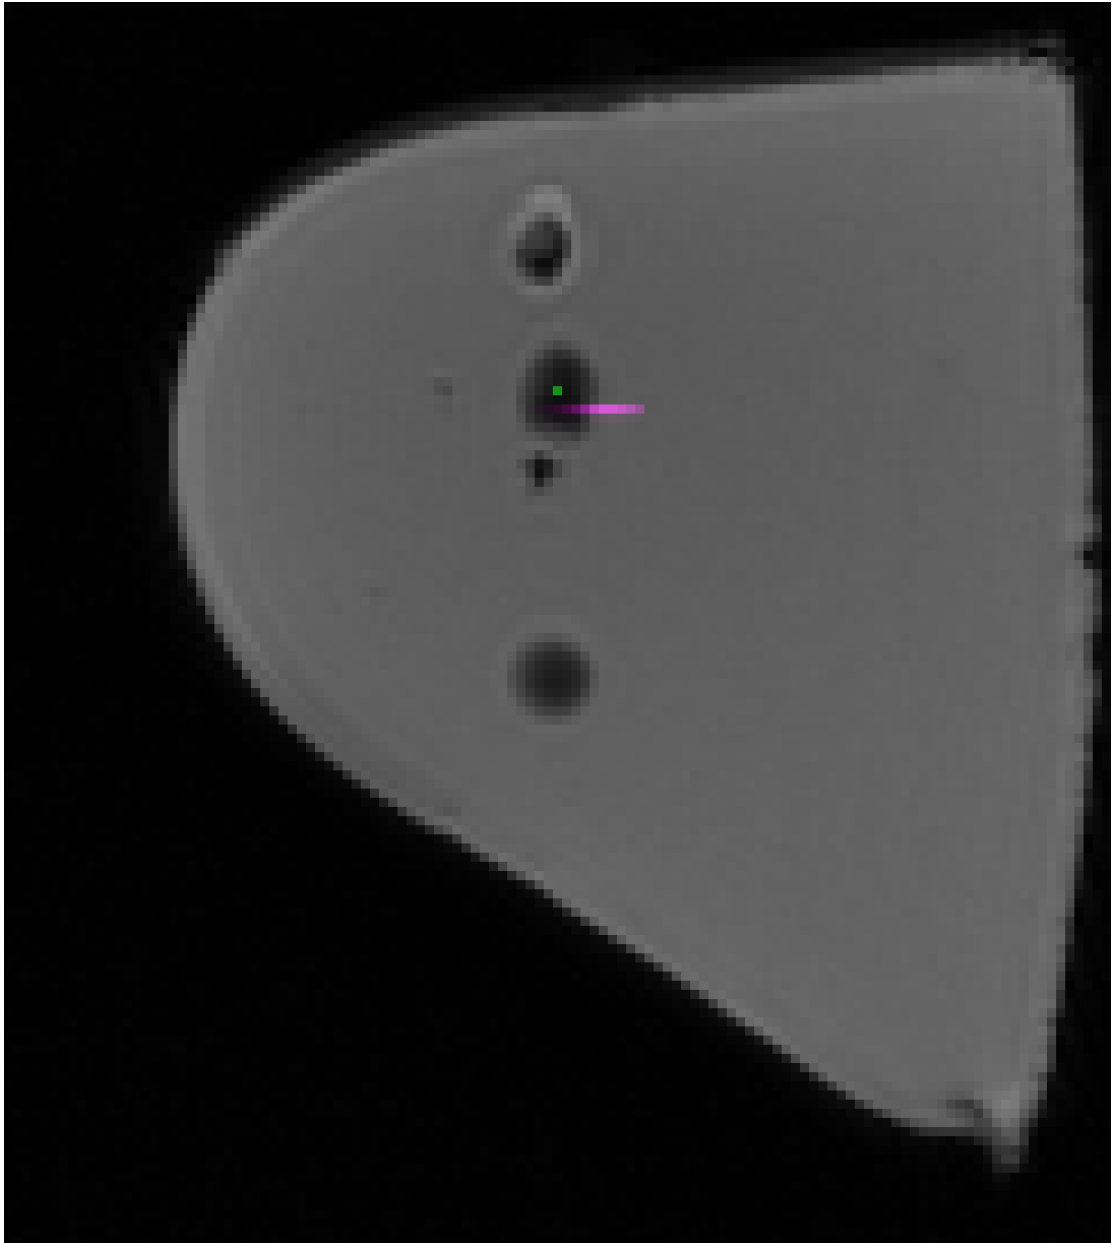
Non-deformed pre-operative/pre-interventional MRI 2D cross section overlayed with the example POI MLPs corresponding 2D cross section (first mapped to grayscale and then to green color) and the approximate expected moved example POI MLPs corresponding 2D cross section (first mapped to grayscale and then to magenta color).
